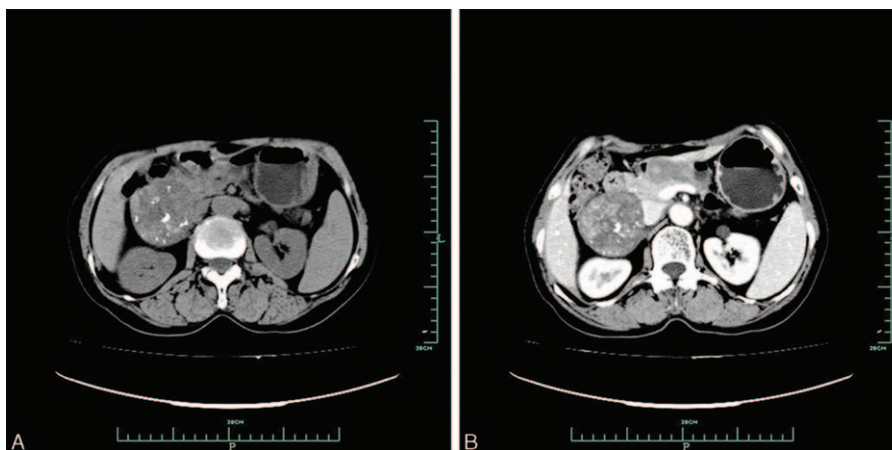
An unenhanced computed tomography (CT) scan showed a well-defined mass (arrow) in the area among duodenum, right liver, and kidney, 5 cm in diameter. The mass was mainly low-density, while regions of high density were visible (A). On the contrast-enhanced CT, the mass was mildly and inhomogeneously enhanced (arrow) (B).
